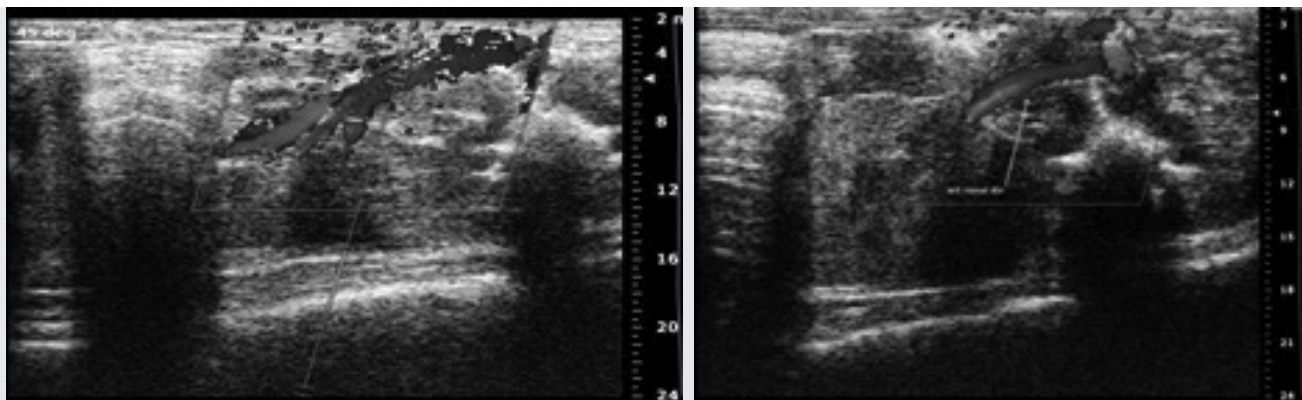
Colour Doppler map of the right renal artery showing the blood drawn with a velocity profile of the parabolic flow.
